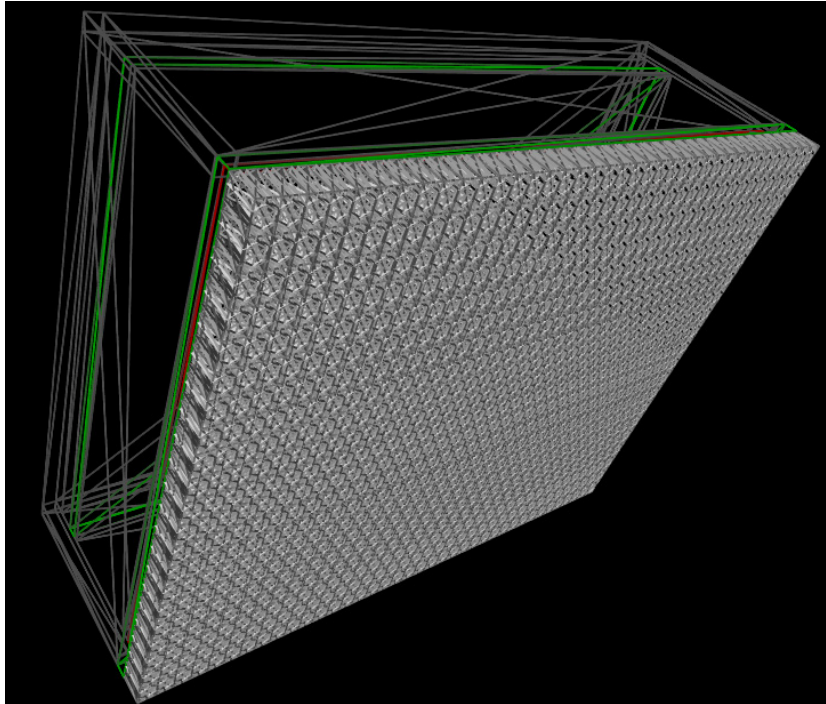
Wireframe model of a SPECT detector head with a LEHR collimator.
